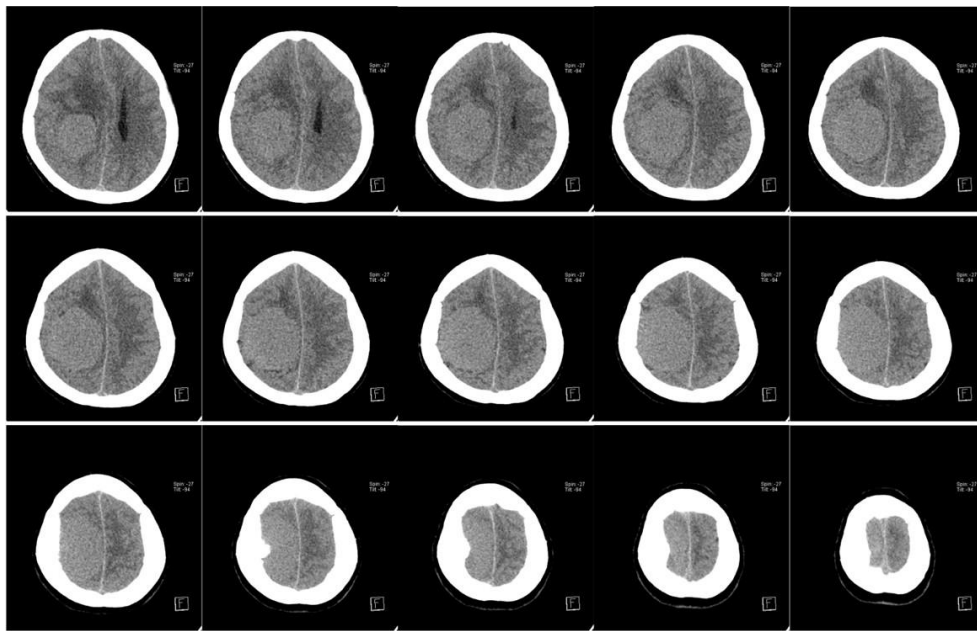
Head CT-Scan without contrast pre-craniotomy.
